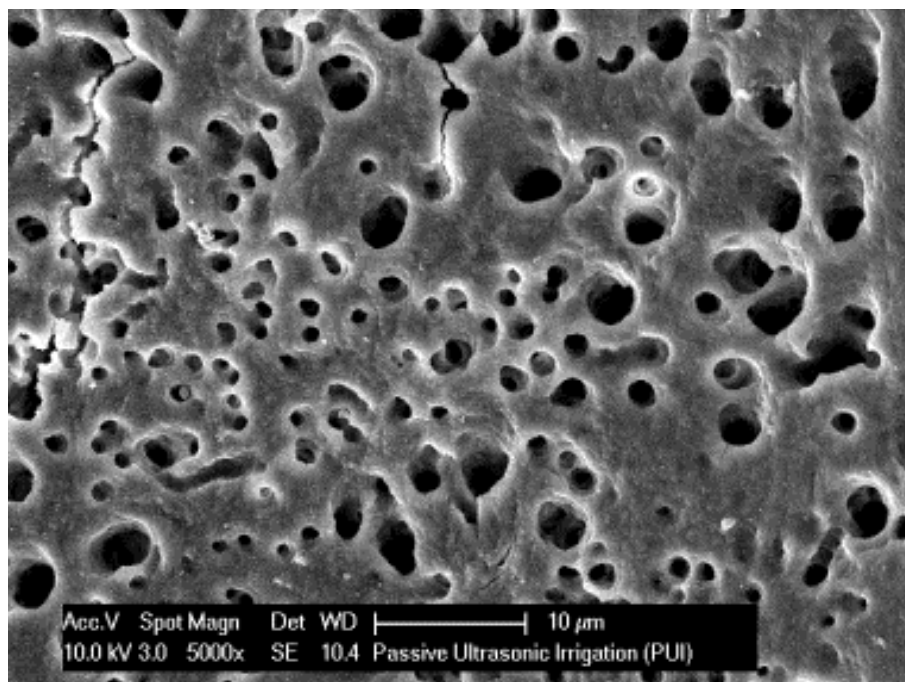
SEM image of the root canal surface following chemomechanical preparation and ultrasonic activated irrigation with 4% NaOCl and 15% EDTAC (5,000 x magnification).
